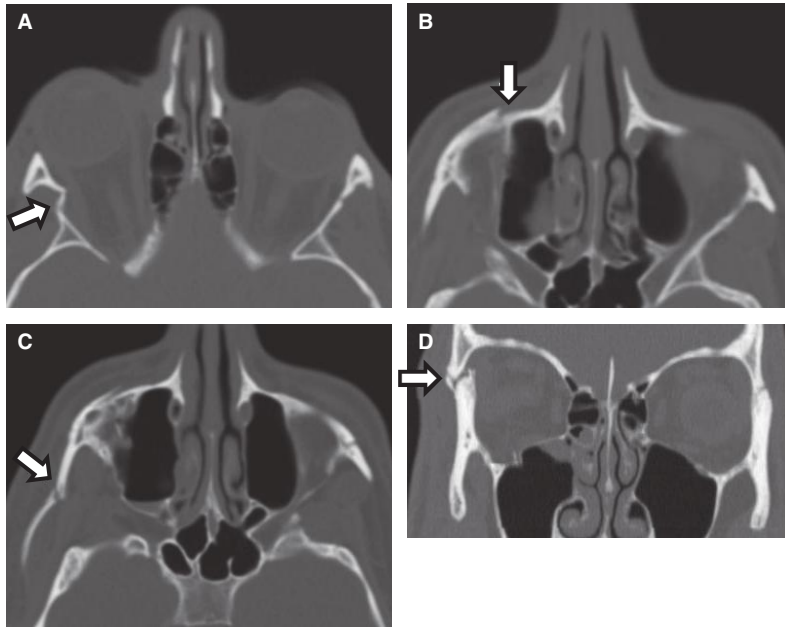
A, Zygomaticomaxillary complex fracture as seen with axial CT. The zygoma is a tetrapod and articulates with the frontal, sphenoid, maxillary, and temporal bones. Fracture of the zygomaticosphenoid suture (*arrow*) leads to angulation of the lateral orbital wall and increased orbital volume. B, Fracture of the zygomaticomaxillary suture (*arrow*). The degree of displacement and rotation of the zygoma is noted. The pull of the masseter muscle on the zygoma leads to this rotational deformity. C, Fracture of the zygomatic arch. Notice the degree of comminution and displacement of the zygomatic arch (*arrow*), which is responsible for establishing the width of the face. D, Fracture of the zygomaticofrontal suture. An axial head CT scan, performed to evaluate for intracranial injury, can show a fracture at the zygomaticofrontal suture. A dedicated CMF CT scan should then be obtained, as was done here, to further delineate the fracture (*arrow*) in the coronal plane.
